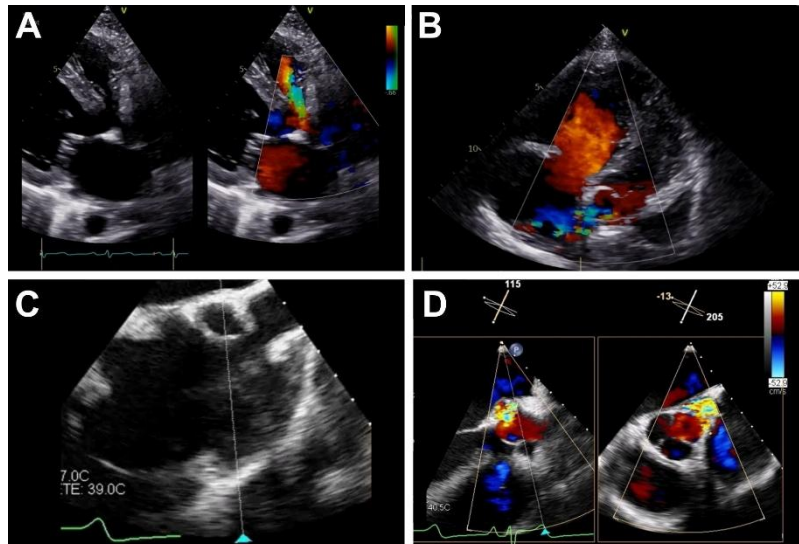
Echocardiographic assesment of ruptured non-coronary sinus of Valsalva aneurysm. Transthoracic and transesophageal ecocardiography demonstrating fistulous communication between the non-coronary sinus of Valsalva and the right atrium (A, B, C, D). Color Doppler images show continuous turbulent flow across the rupture site (A, B, D).
